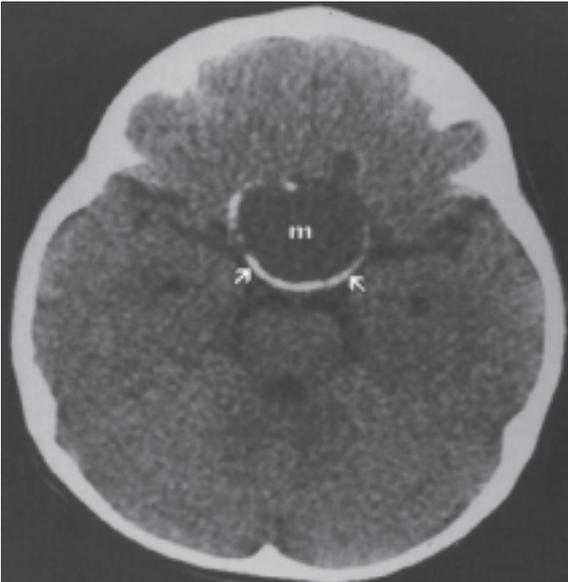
Unenhanced axial CT scan of child with craniopharyngioma shows hypodense mass (m) at suprasellar region with rim calcification (arrows).
